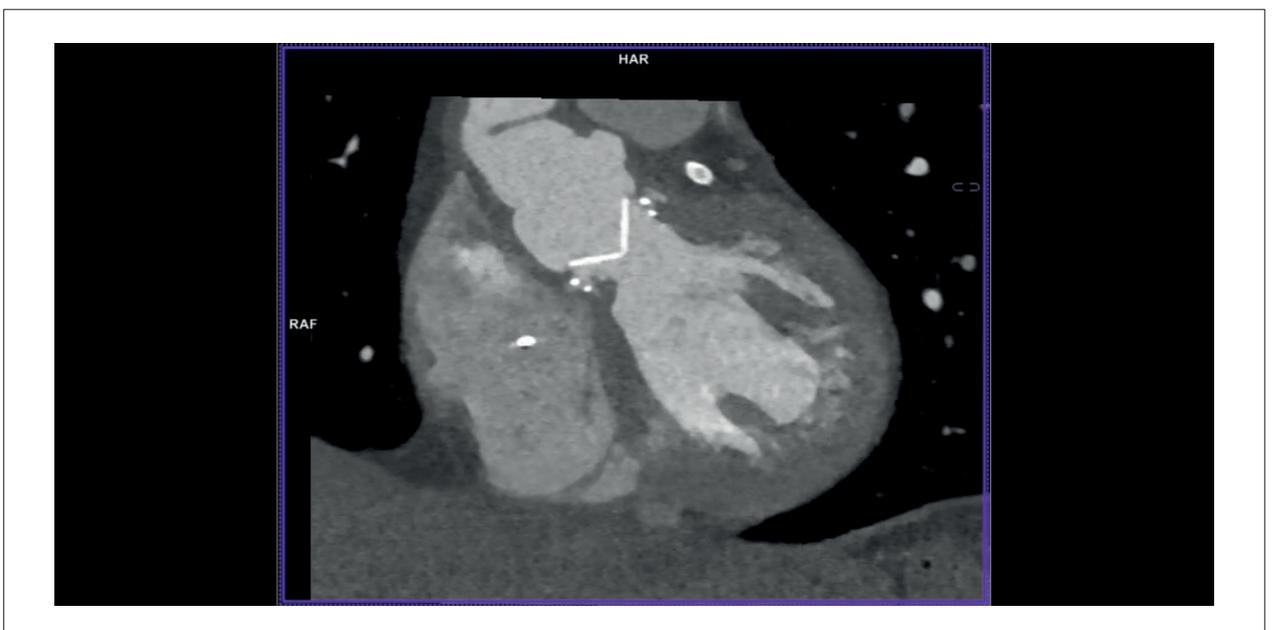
1A) Cardiac CT scan at admission showing vegetation in the aortic valve and inflammatory changes in the intervalvular fibrosa and inter-atrial septal spaces. 1B) Cardiac CT scan at discharge with residual inflammatory tissue.
